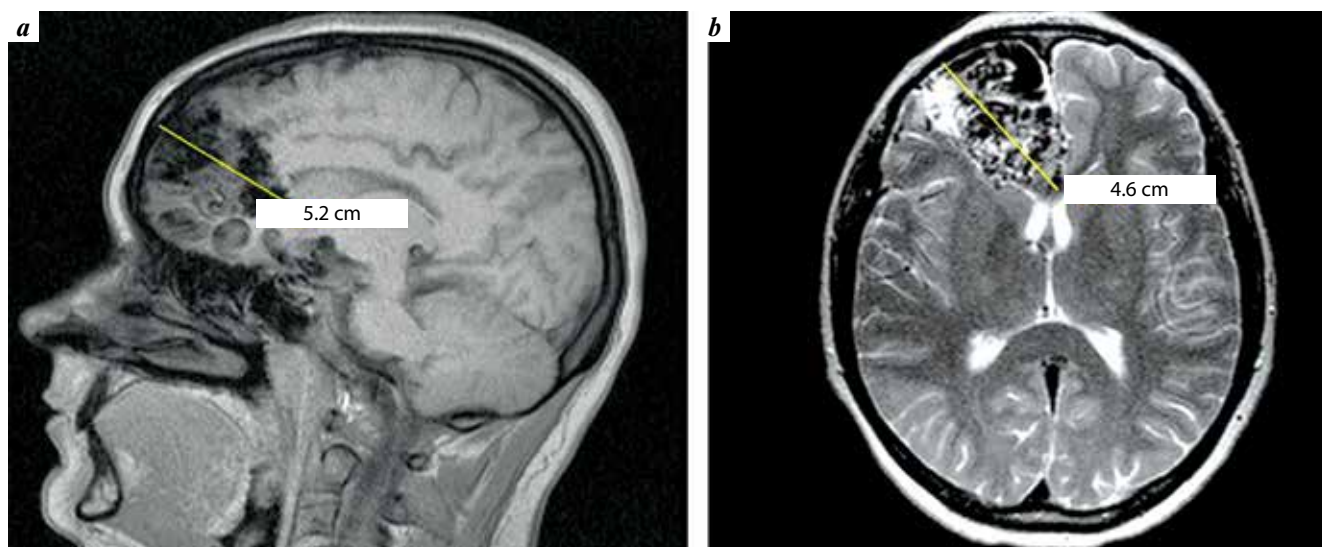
Brain MRI: a – sagittal projection, T1-weighted; b – axial projection, T2-weighted
